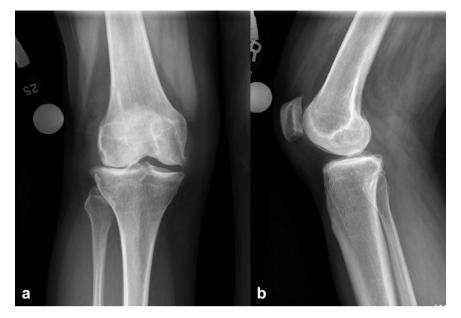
Preoperative standing (a) anteroposterior (AP) and (b) lateral right knee radiographs demonstrating valgus osteoarthritis.
